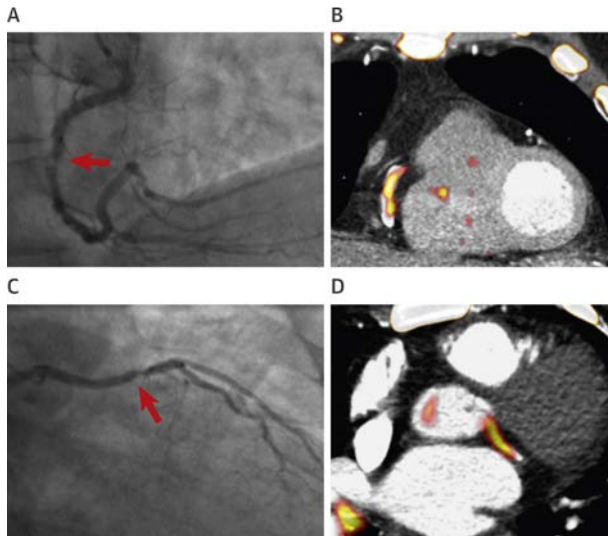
Two examples of patients suffering an ACS. Culprit lesions in the right (A) and circumflex (C) coronary artery on invasive angiography. (B) and (D) show the fused CT and invasive angiography studies with intense uptake of $^{18}\text{F-NaF}$ in the respective culprit lesions. Source: fig. 5 of Ref. [19.30].
